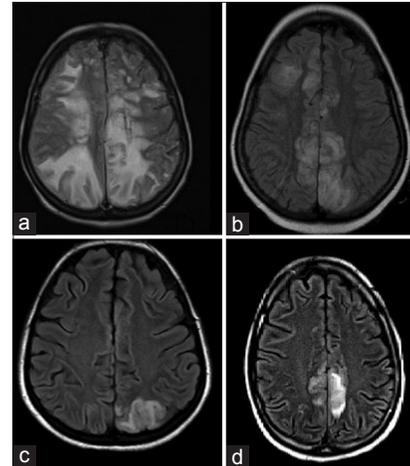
Four main magnetic resonance imaging patterns of posterior reversible encephalopathy syndrome. (a) Holohemispheric watershed pattern. Fluid-attenuated inversion recovery (FLAIR) sequences showing bilateral vasogenic edema in a linear pattern involving the white matter of the cerebellum and brainstem, (b) superior frontal sulcus pattern. FLAIR sequences are showing bilateral vasogenic edema in a nonconfluent pattern involving the frontal sulcus area, (c) dominant parietal-occipital pattern. FLAIR sequences showing bilateral vasogenic edema in the white matter of the occipital and parietal lobes, (d) partial expression of the three primary patterns
